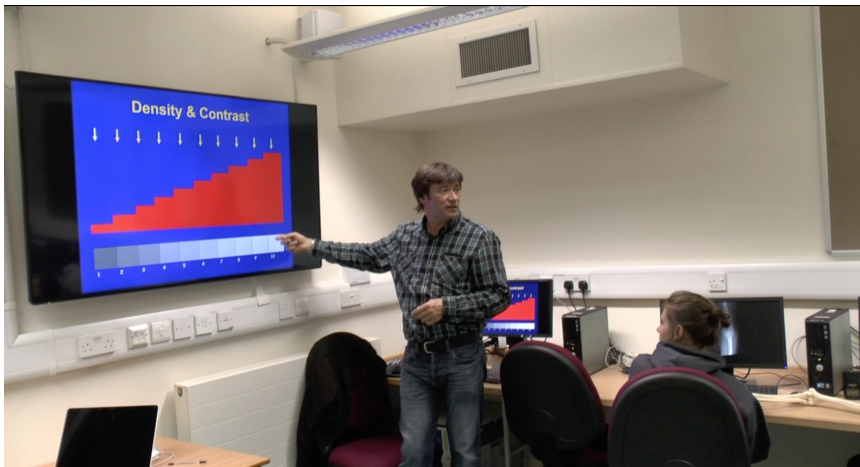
'If you look on here, it's basically saying you can either have something that's very thick or very dense it's going to absorb a lot of x-rays...so it's going to go white, okay?'
